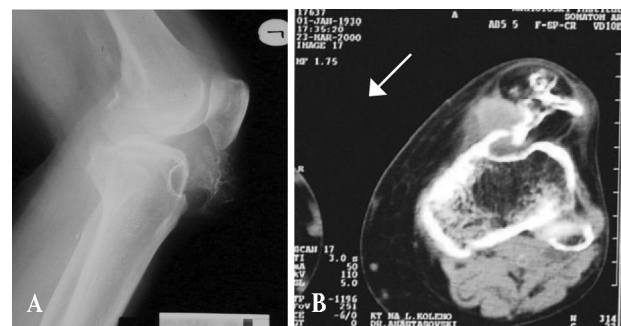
A. Lateral X-ray of the knee shows the localization of the chondroma. B. Transverse section on computer tomography of the knee shows proximal tibia, chondroma and posttraumatic hematoma (arrow)*
